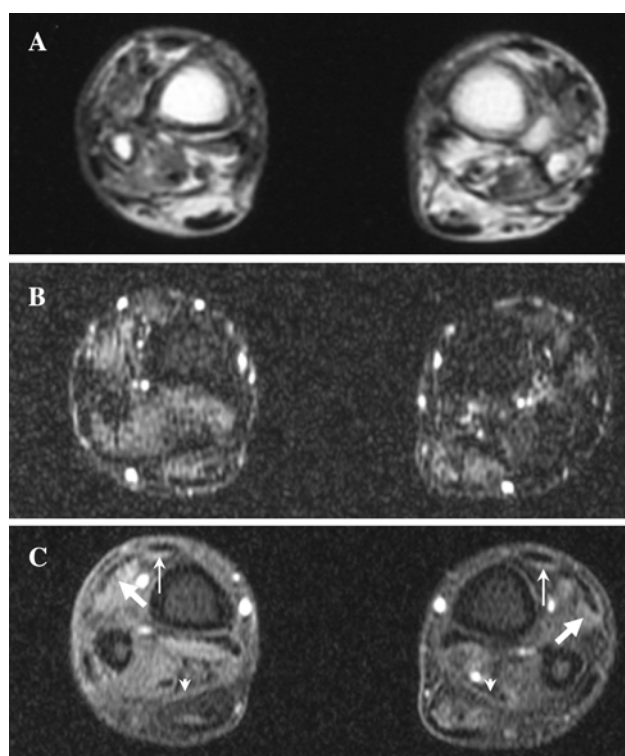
Crus MRI in case 2 performed on day 21. a, b and c are T1-weighted, T2-weighted (fat suppression) and gadolinium-enhanced T1-weighted (fat suppression) axial images, respectively. In c, *thin arrows* indicate contrast enhancement along the fascia of the tibialis anterior. *Thick arrows* demonstrate contrast enhancement along the fascia of extensor digitorum longus. *Arrowheads* depict contrast enhancement along the fascia of soleus. The enhancement is apparent in comparison with a
